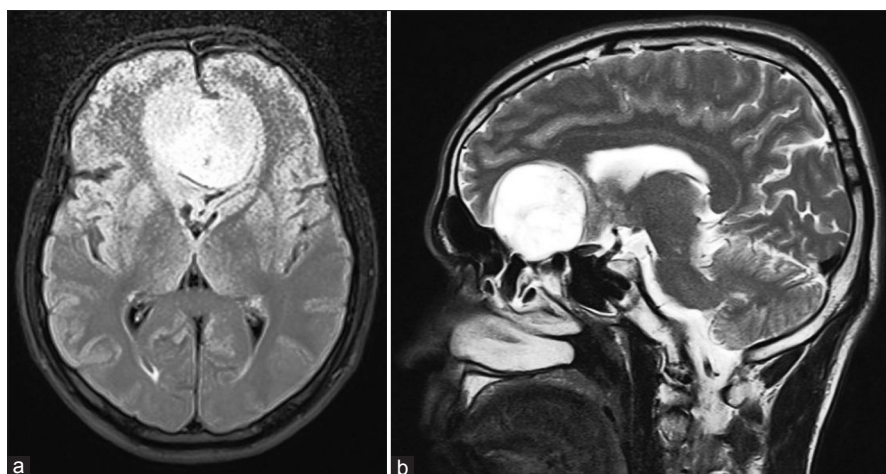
(a and b) Magnetic resonance imaging of brain – well-defined heterogeneously enhancing altered signal intensity extra-axial lesion with a broad base toward the dura in the frontal region, (a) axial view; (b) sagittal view
